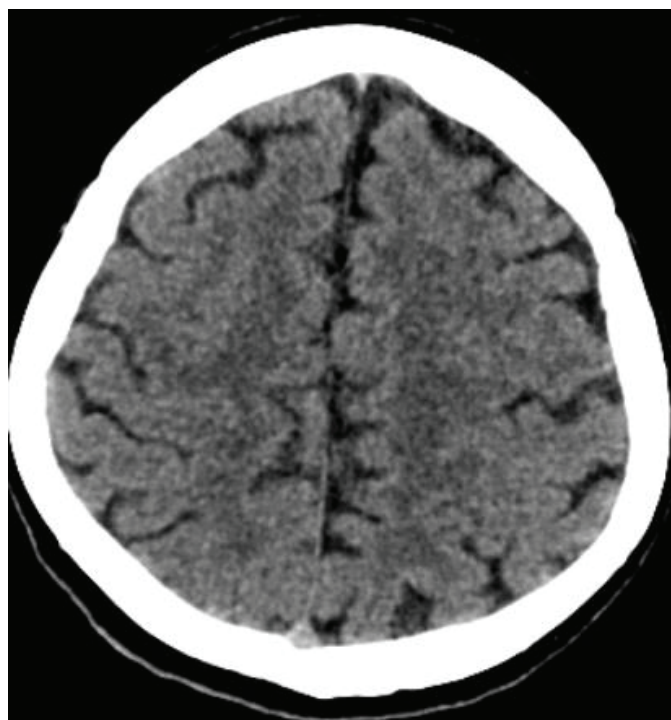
Initial brain CT scan, showing a normal finding.
